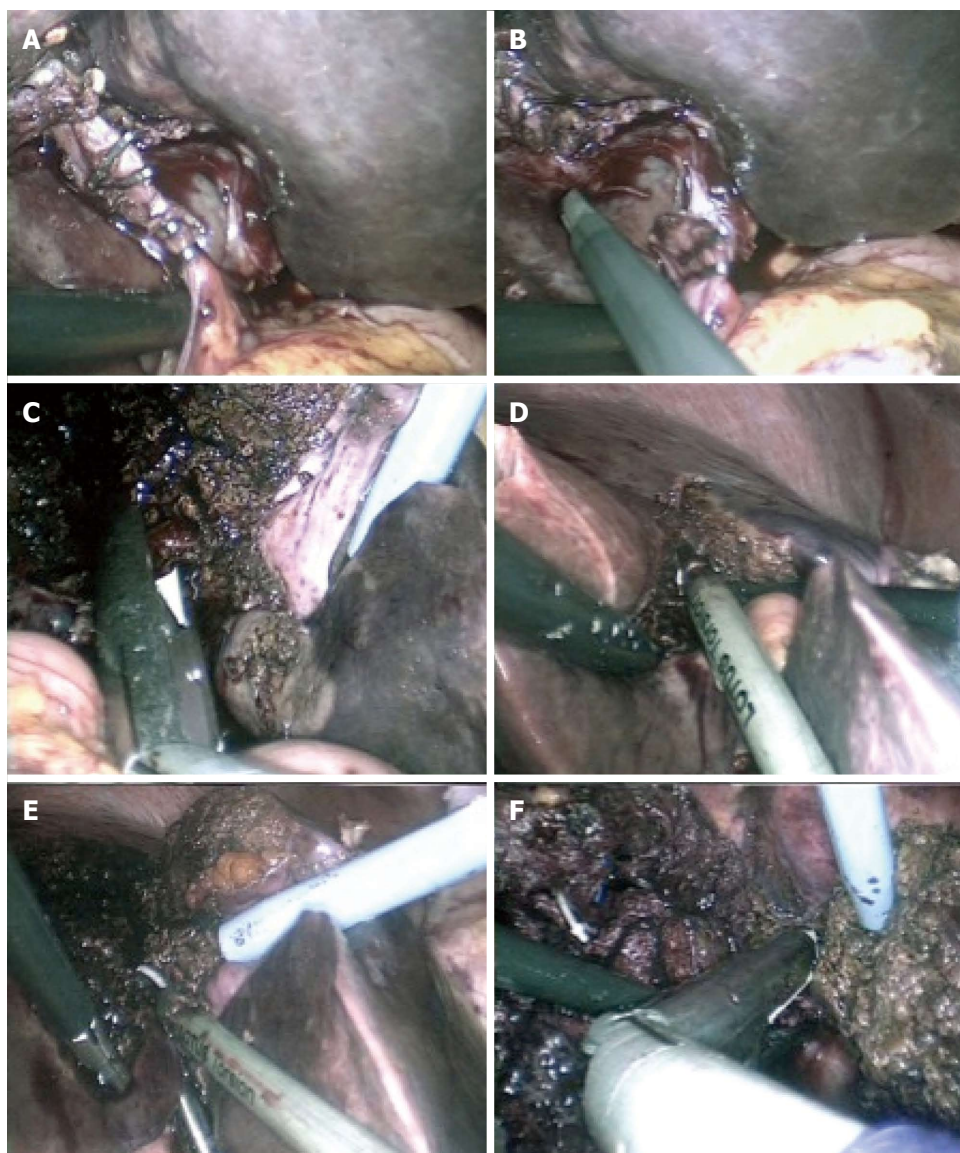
The operation. A and B: Identification, dissection, and clip ligation of the replaced left hepatic artery; C: Dissection of the left portal vein; D and E: Parenchymal transection using the Lotus Ultrasonic Scalpel; F: Dissection of the left hepatic vein.
